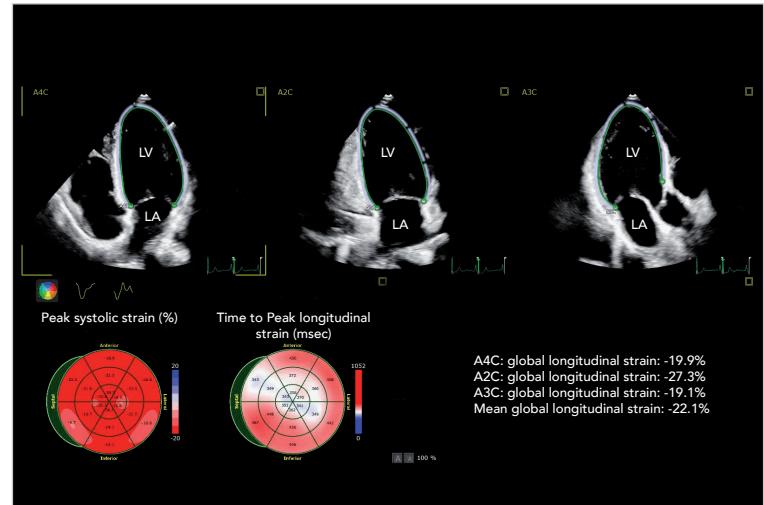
// Strain echocardiography of a structural normal left ventricle.
